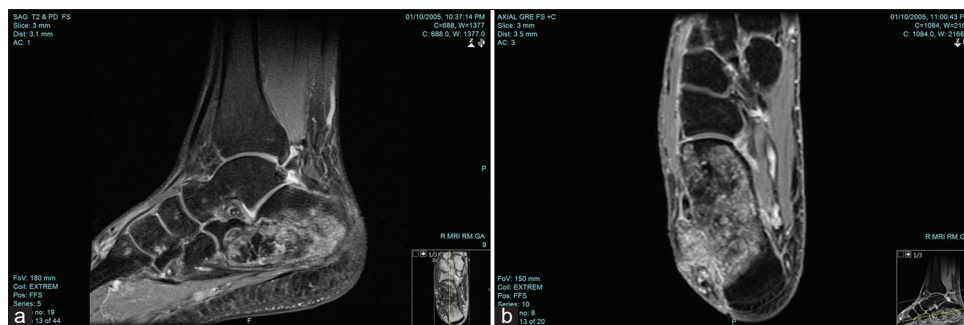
Magnetic resonance imaging showing involvement of almost the whole calcaneum (a) sagittal section and (b) axial sections with some lateral soft-tissue component.
